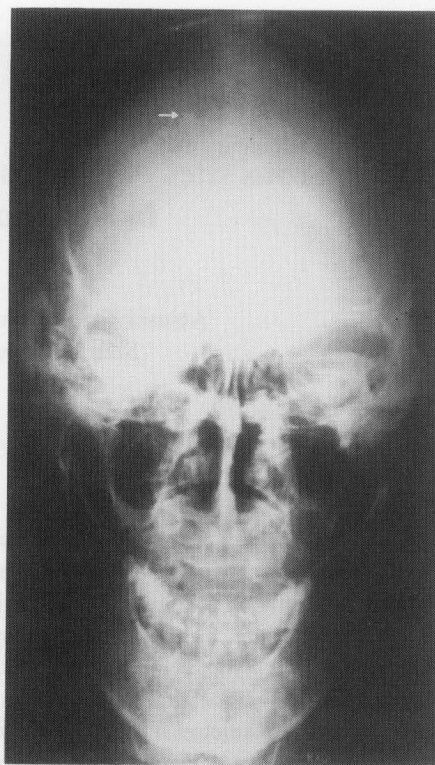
The radiograph of the skull showed a round and well-defined osteolytic lesion on the parietal bone (arrow). Marginal sclerosis was not seen.
